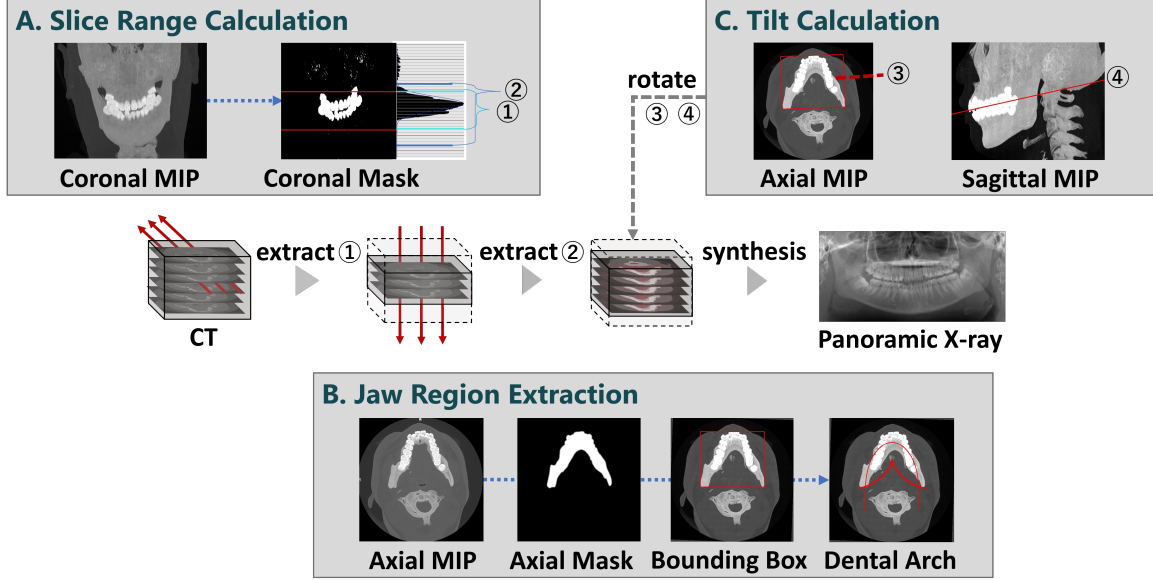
Overview of the proposed method for panoramic X-ray synthesis.
